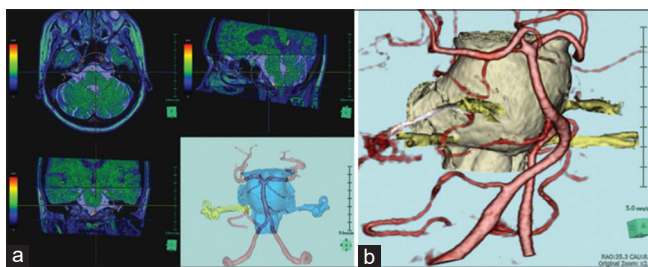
(a) Workstation display on fusing magnetic resonance imaging and computed tomographic angiogram images. (b) The result of fusion
